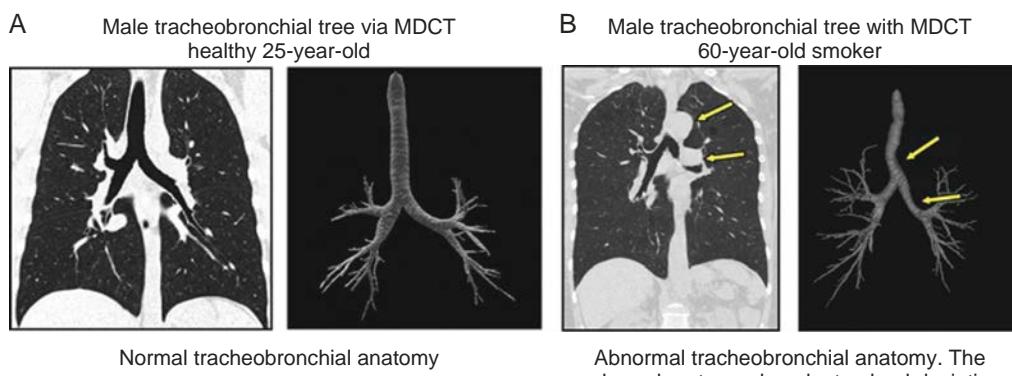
(A) The multidetector CT scan and also three-dimensional view of tracheobronchial anatomy in a healthy volunteer. (B) Abnormal tracheobronchial anatomy in a 60-year-old smoker. The arrows show enlarged aorta (left) and the deviation of the trachea toward the right caused by the enlarged aorta (right). *CT*, Computed tomography.
